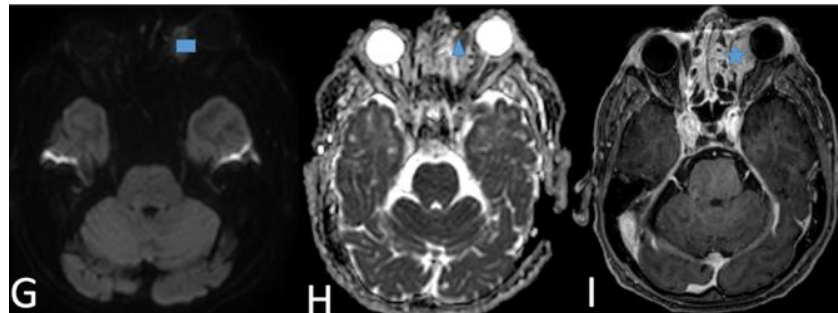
MRI of chronic fibrosing IOI. DWI at $b = 1000 \text{ s/mm}^2$ (H) shows a hyperintense inferomedial orbital mass. The ADC map (I) confirms restricted diffusion ($\text{ADC} < 1.0 \times 10^{-3} \text{ mm}^2/\text{s}$). Gadolinium-enhanced 3D T1 VIBE with fat suppression (J) demonstrates avid contrast enhancement, consistent with active fibrosing inflammation.
